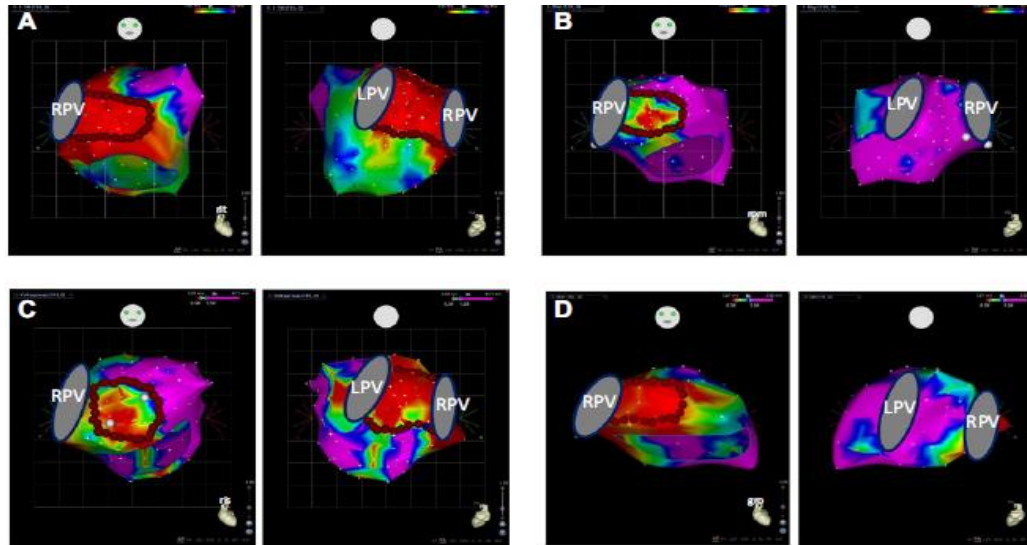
Four Stages of Left Atrial Tissue Fibrosis Based on 3D Delayed Enhancement Magnetic Resonance Imaging Scans
